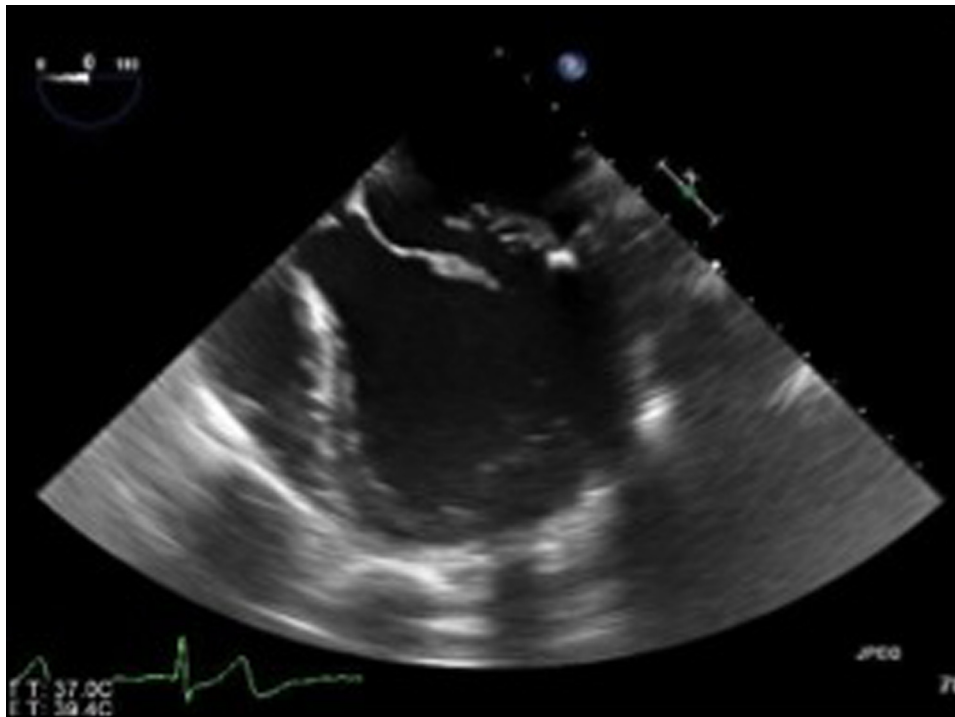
Five-chamber 2-dimensional transesophageal echocardiogram showing a thickened and prolapsed P2 segment.
